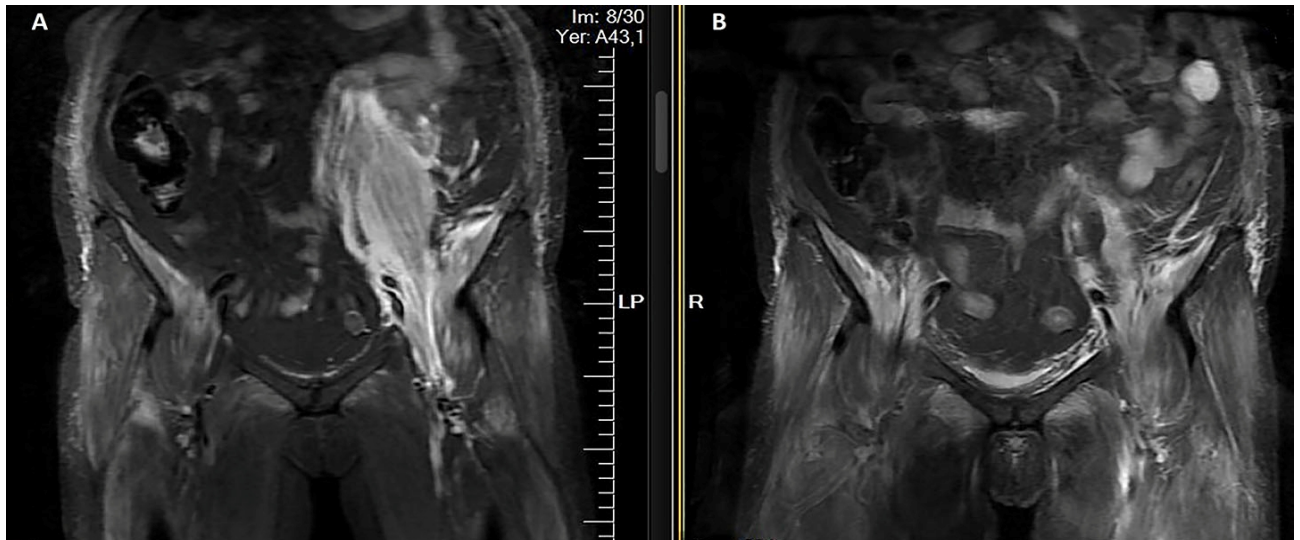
Coronal fat-suppressed T2-weighted images A and B; high signals in pelvic and proximal thigh muscles indicates myositis.
